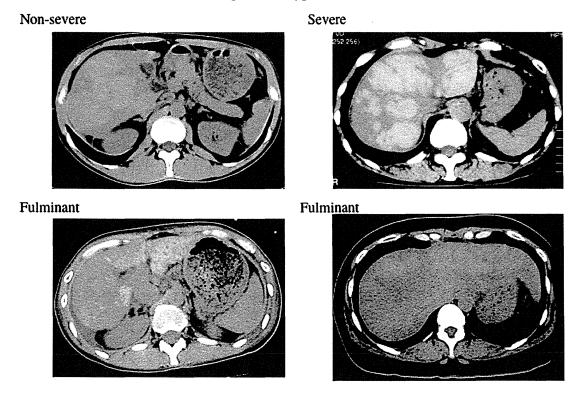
Heterogeneous hypoattenuation pattern on unenhanced CT in acute onset AIH. Patients with autoimmune ALF often show a variety of heterogeneous hypoattenuation
